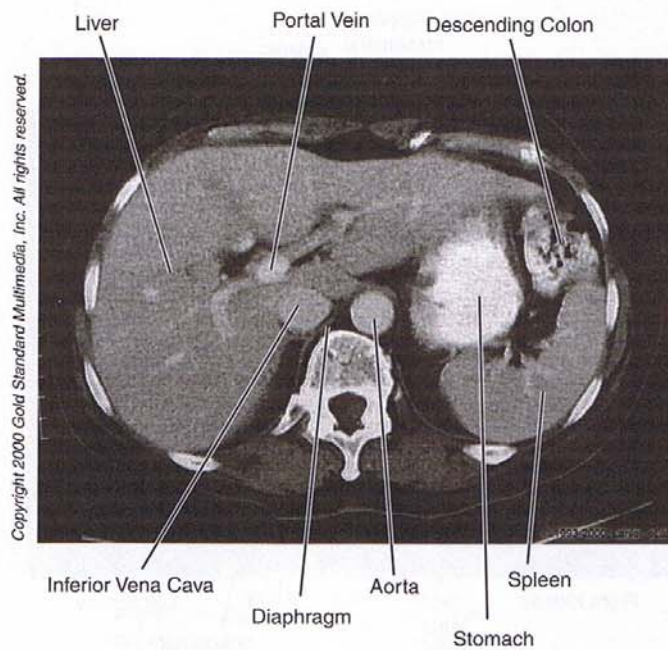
Abdomen: CT, T₁₂
